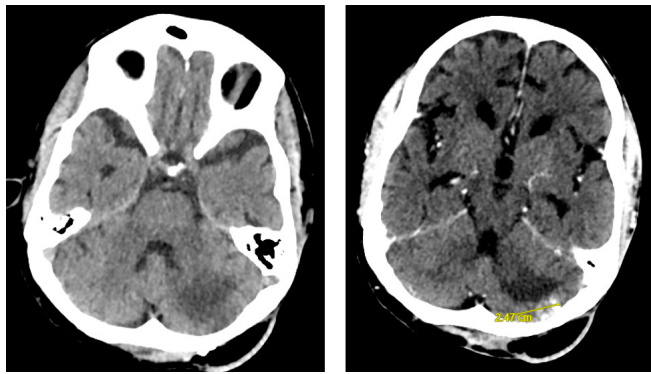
Non Injected (Left) and Injected (right) Cerebral computed Tomography showing the radiological signs of cerebral radionecrosis in the left cerebellum area.
